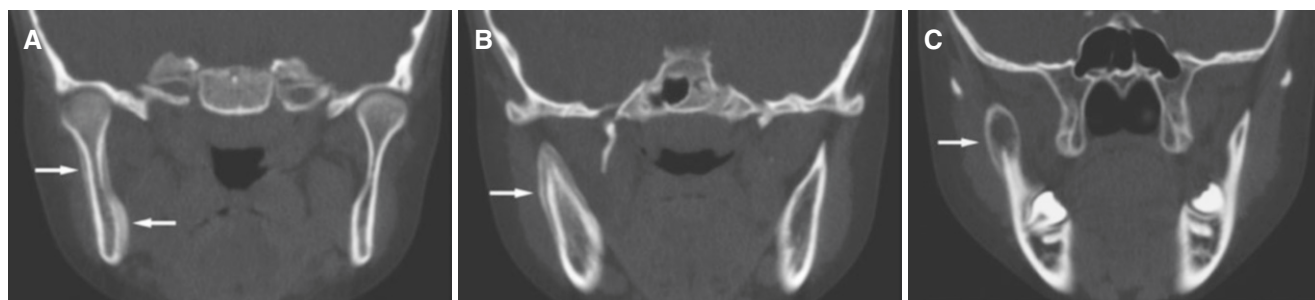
Osteomyelitis with periostitis, mandible; 10-year-old female with variable facial swelling and restricted mouth-opening capacity. (A) Coronal CT image shows periosteal reaction buccally and lingually
